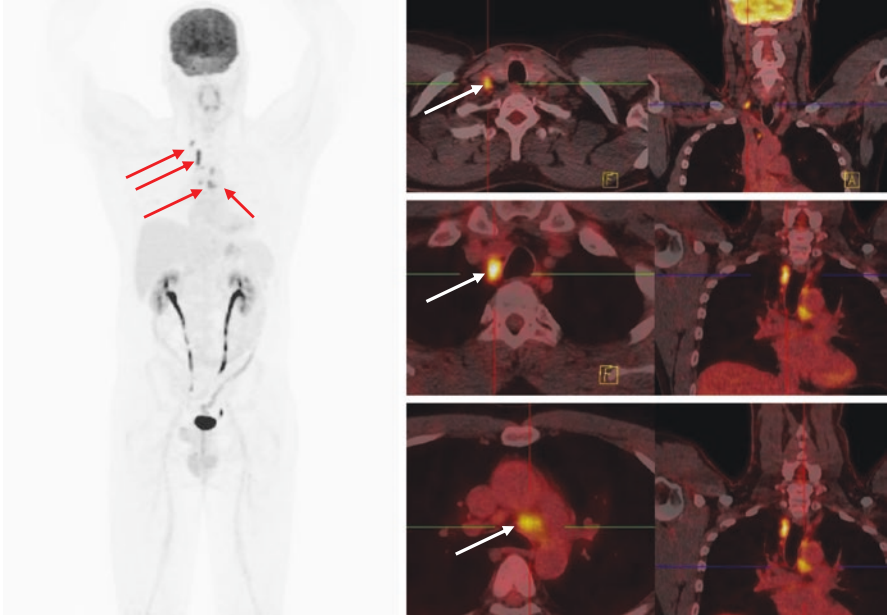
FDG PET CT performed to look for potential systemic causes in a case of bilateral uveitis. This demonstrated FDG-avid intra-thoracic right paratracheal, aorto-pulmonary window and right supraclavicular lymph nodes (borderline by CT size criteria, red arrows). Endobronchial ultrasound guided fine needle aspiration of the right paratracheal nodes (white arrows) showed non-caseating granulomas. TB PCR negative, positive quantiferon test. On this basis anti-tubercular therapy was started, resulting in improvement of the eye symptoms
